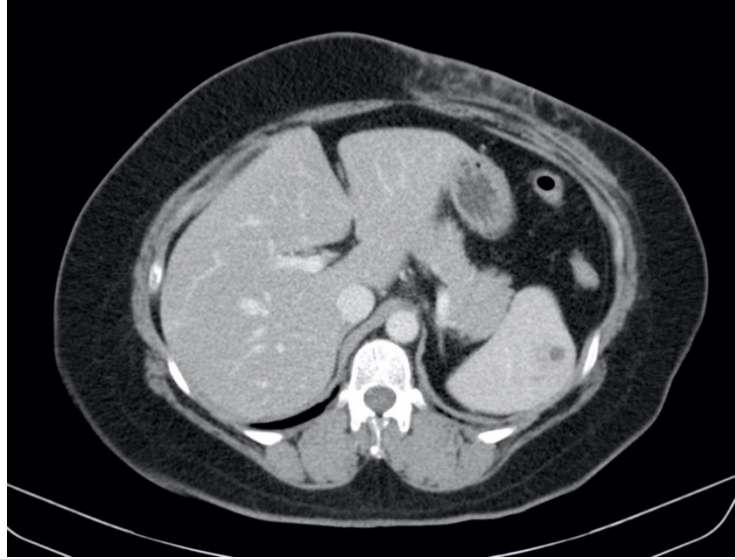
CT abdomen post wide local excision of tumor; prior to commencement of radiotherapy
